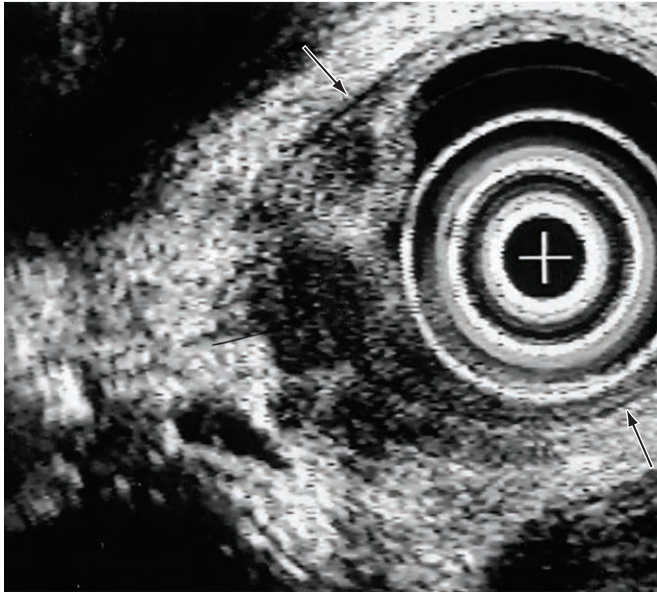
Upper,* A T3 tumor as seen on esophageal ultrasound. The hypoechoic (black) tumor breaches the boundary between the fourth and fifth ultrasound layers (*arrows*) and invades the hyperechoic (white) fifth ultrasound layer (periesophageal tissue). *Lower,* A T3 tumor invades the periesophageal tissue but does not involve adjacent structures.
